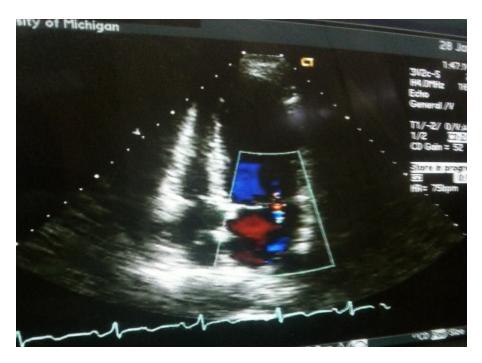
color Doppler image showed mitral valve regurgitation for 70 years old male.
